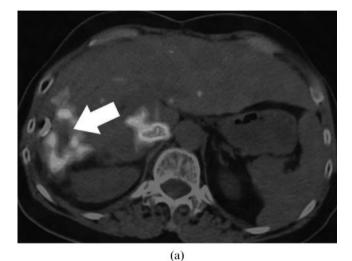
56-year-old female with recurrent hepatocellular carcinoma (HCC) in the right lobe underwent yttrium-90 (90 Y) selective internal radiation therapy. She was previously treated by radiofrequency ablation and liver resection. HCC recurrence was in the caudate lobe and periablation cavity region. A total of 1.2 GBq of 90 Y resin microspheres was injected via the right hepatic artery. Pre-therapy triphasic CT liver (delayed phase) shows an ablation cavity (arrow) in segment VII/VIII—(a) transaxial; (b) coronal.
